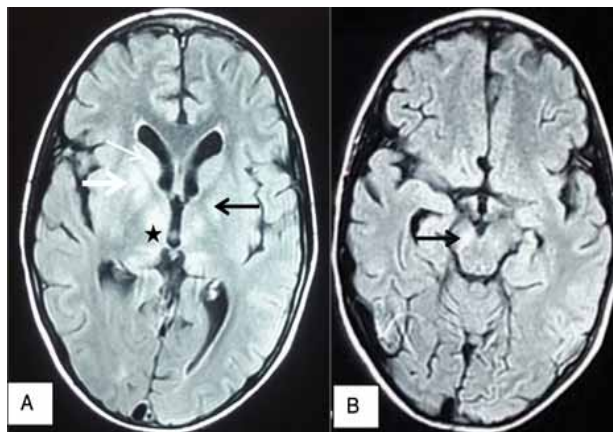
A. FLAIR image MRI brain (axial view) of patient showing hyperintensities in bilateral caudate (thin arrow), putamen (thick arrow), globus pallidus (black arrow) and thalami (asterisks) B. Hyperintensity in right substantia nigra (arrow).
